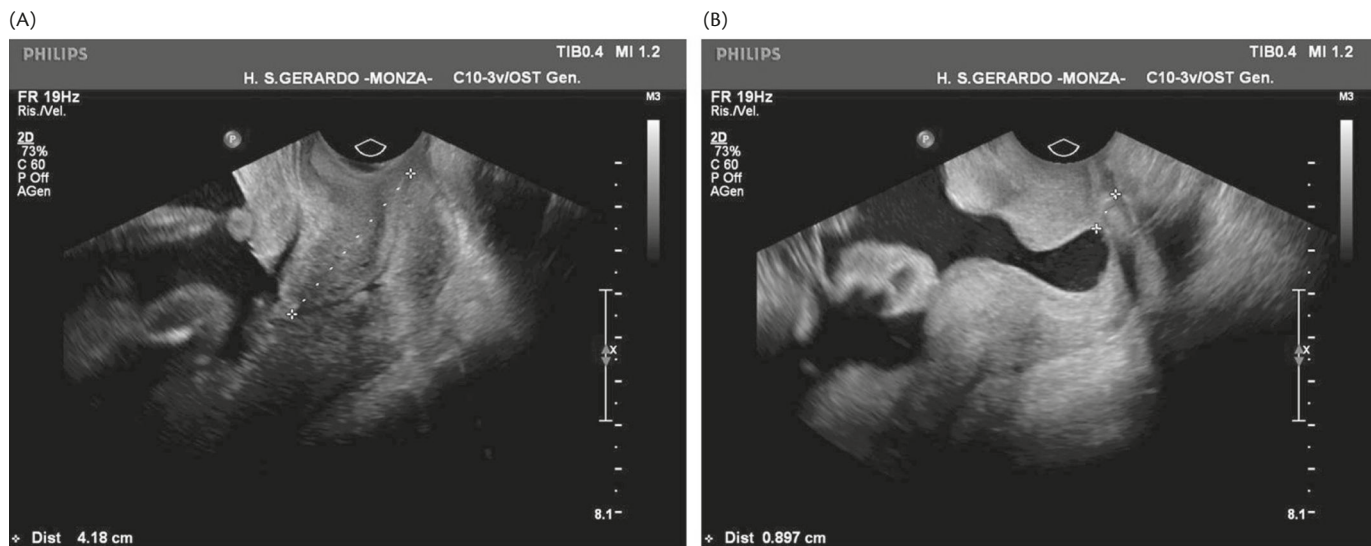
Cervical sonography for the prediction of preterm birth. (A) Normal findings. (B) Patient at high risk because of cervical incompetence. Reproduced with permission from the University Hospitals San Gerardo, Monza, Italy.
